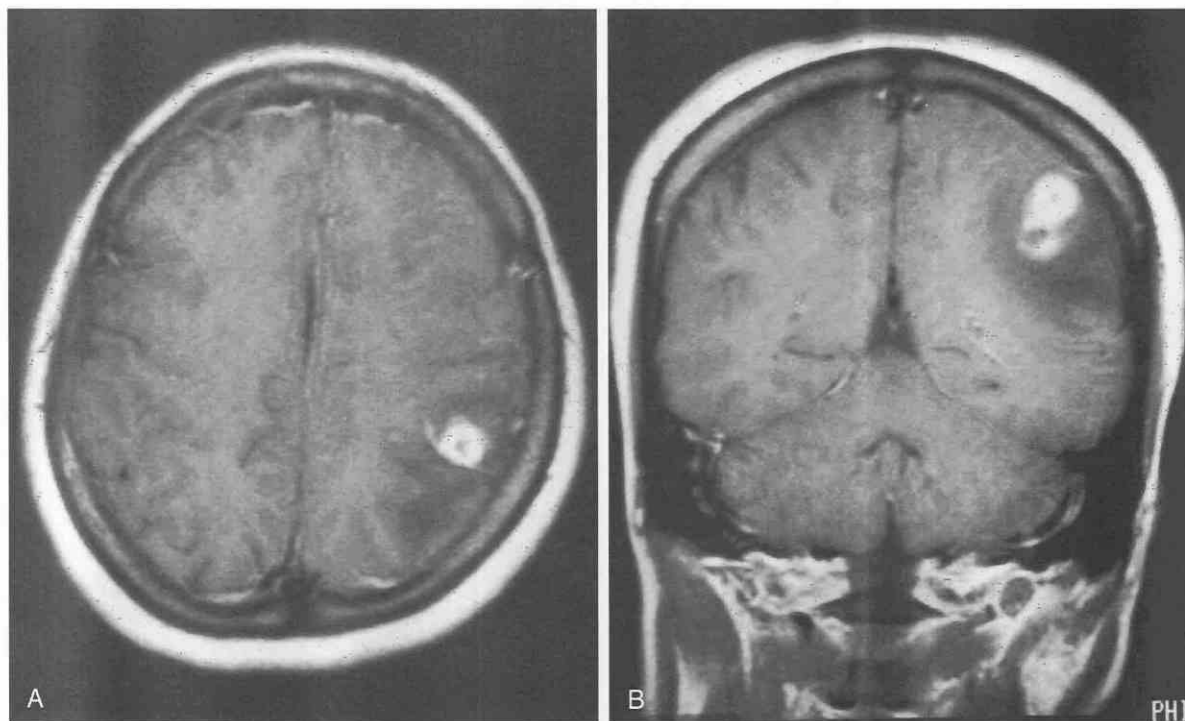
Late cerebritis. A, Gadolinium-enhanced MRI study shows thick, smooth, ringlike enhancement with surrounding edema. B, Gadolinium-enhanced MRI study (coronal view) shows a second, small, adjacent ringlike enhancement.
